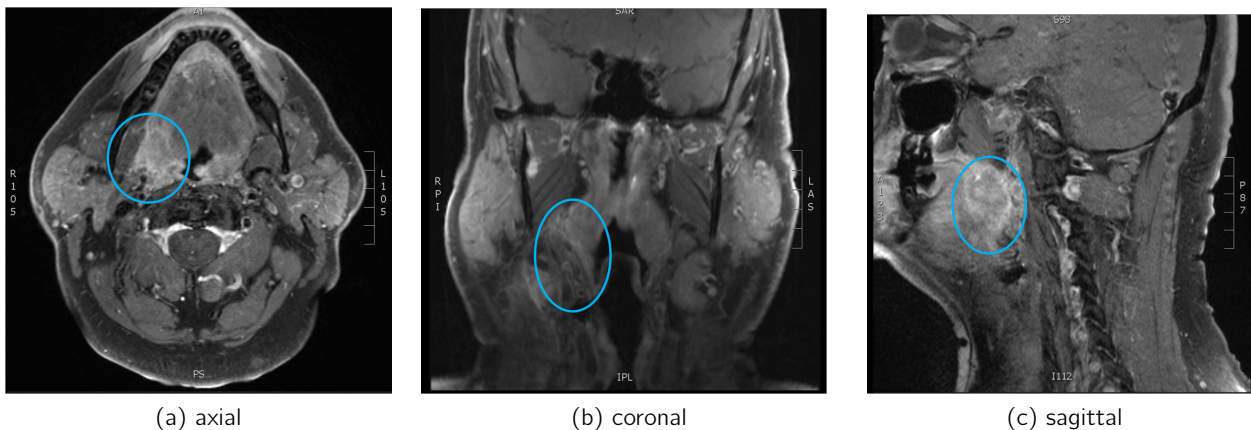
The tumour in the right tonsil loge in three different views on MRI, T1 weighted, contrast enhanced, turbo spin echo sequence
